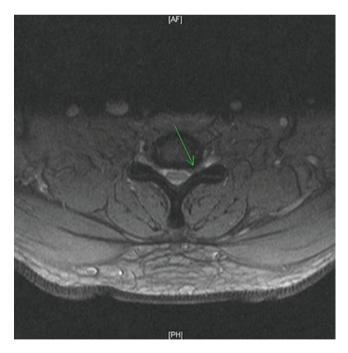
Axial T2 MRI with leftward C6–C7 disk herniation identified by *arrow*
